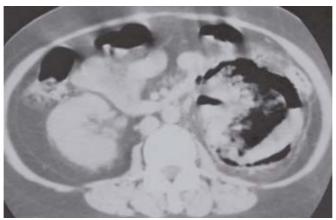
Unenhanced axial CT image of the kidneys.
